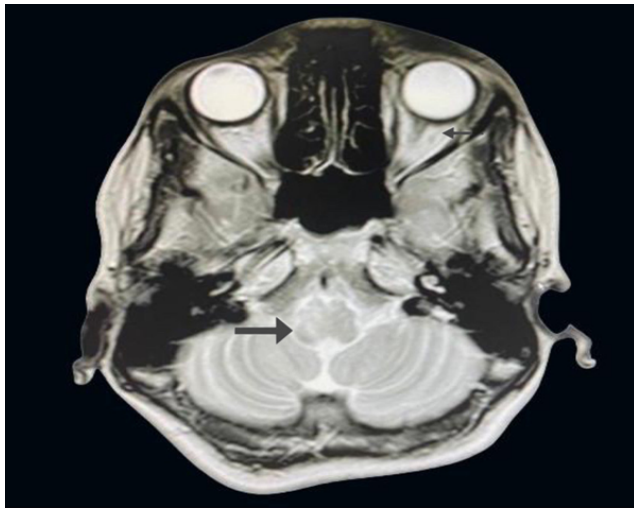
MRI showed a T2/FLAIR hyperintensity in bilateral middle cerebellar peduncle, dentate nuclei, dorsal midbrain, pons and medulla
